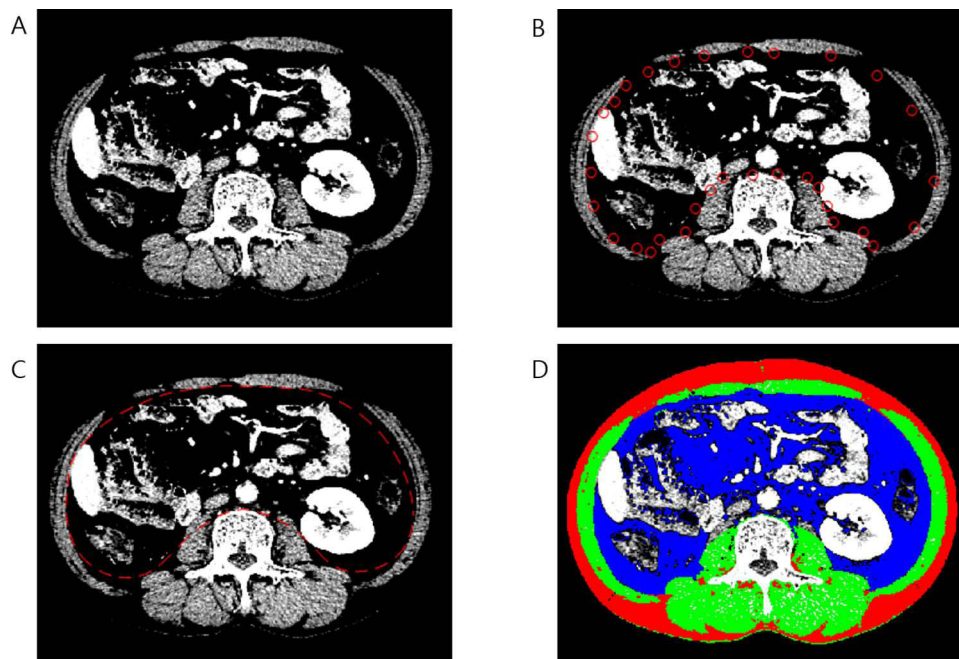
Semiautomatic quantification of body composition in a 58-year-old male with metastatic renal cell carcinoma. To enhance the visibility of muscle boundaries, computed tomography (CT) image intensity was linearly transformed into a range of 0 to +100 Hounsfield Units (HU) (A). Following semiautomatic manipulation (B), the active contour method is used to detect the boundary between muscles and inner tissues by minimizing a cost function, thereby segmenting CT images into inner and outer regions (C). Subsequently, pixels corresponding to fat and muscle are identified using predefined cut-off values of –300 to –50 HU and –29 to +150 HU, respectively. Regions of muscle, subcutaneous fat, and visceral fat are displayed as color-coded in green, red, and blue, respectively (D). The cross-sectional areas of muscle, subcutaneous fat, and visceral fat are quantified at 140.18 cm², 94.95 cm², and 186.46 cm², respectively. CT, computed tomography; HU, Hounsfield unit.
